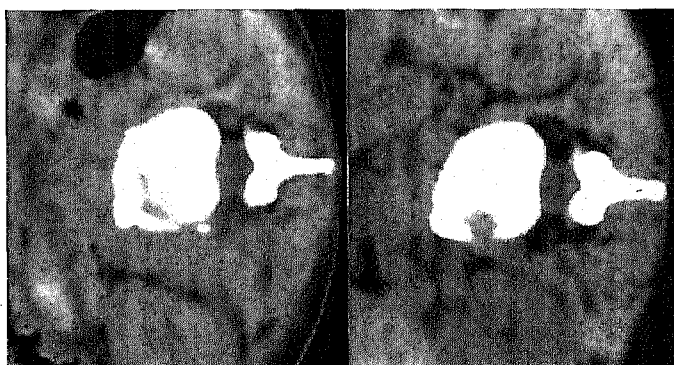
CT scan of the third vertebral body at the level of the intervertebral foramen.
